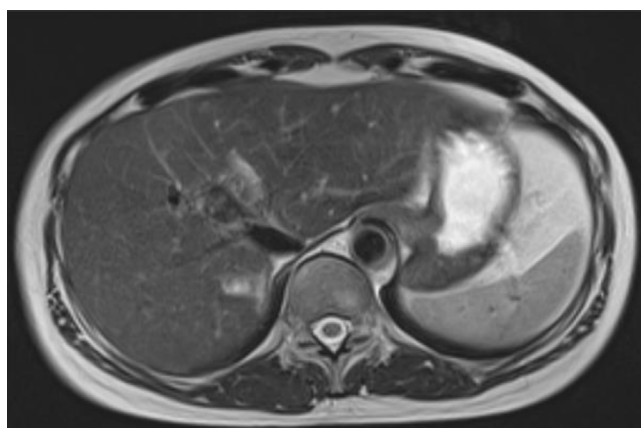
T2-weighted MRI showed that the size of the giant hepatic hemangioma had reduced to 29 × 15 mm and maintained for 15 years after proton beam therapy.
